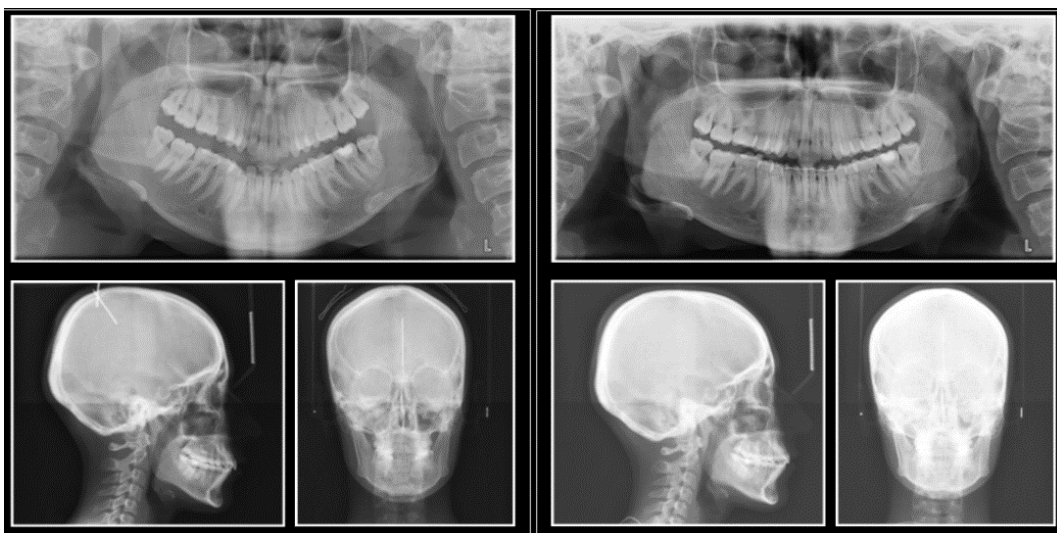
Initial and final radiographs of Case 2.
